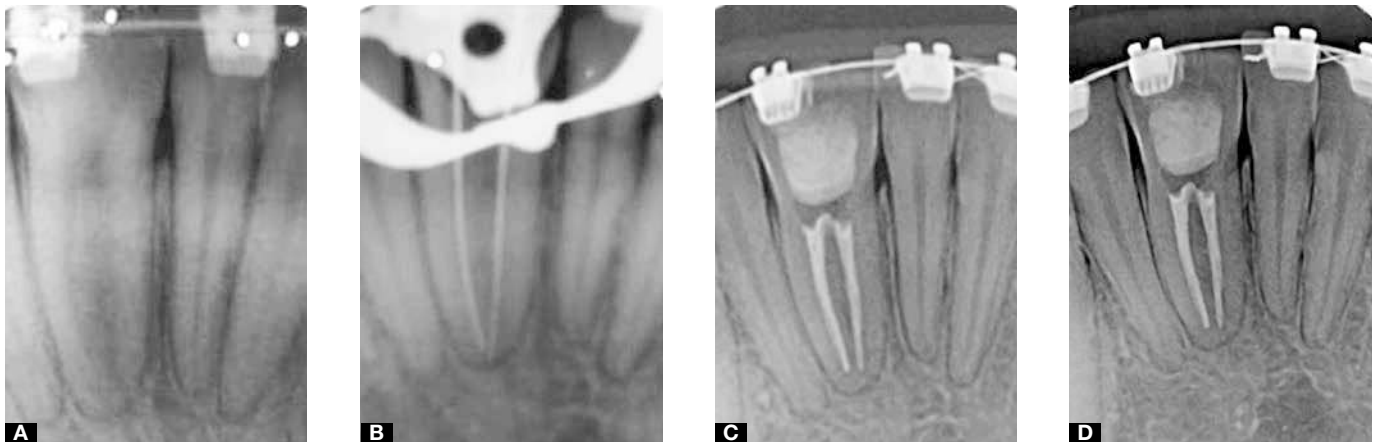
A) Image of periapical radiograph showing normal aspect and differentiated anatomy, featuring the dental element fusion and the presence of single root with two radicular canals. B) Determination of working length. C) Root canal filling and tooth sealed with universal restorative. D) One year follow-up.
